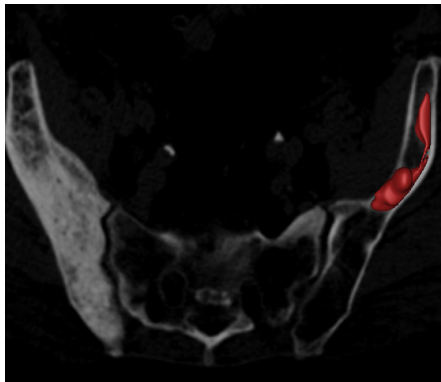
An example of correctly labelling a lesion lytic. My algorithm labelled this lesion by symmetrically comparing the CBM trabecular bone density measurements. The CT data is from the Addenbrooke's Hospital CT Data Collection.
